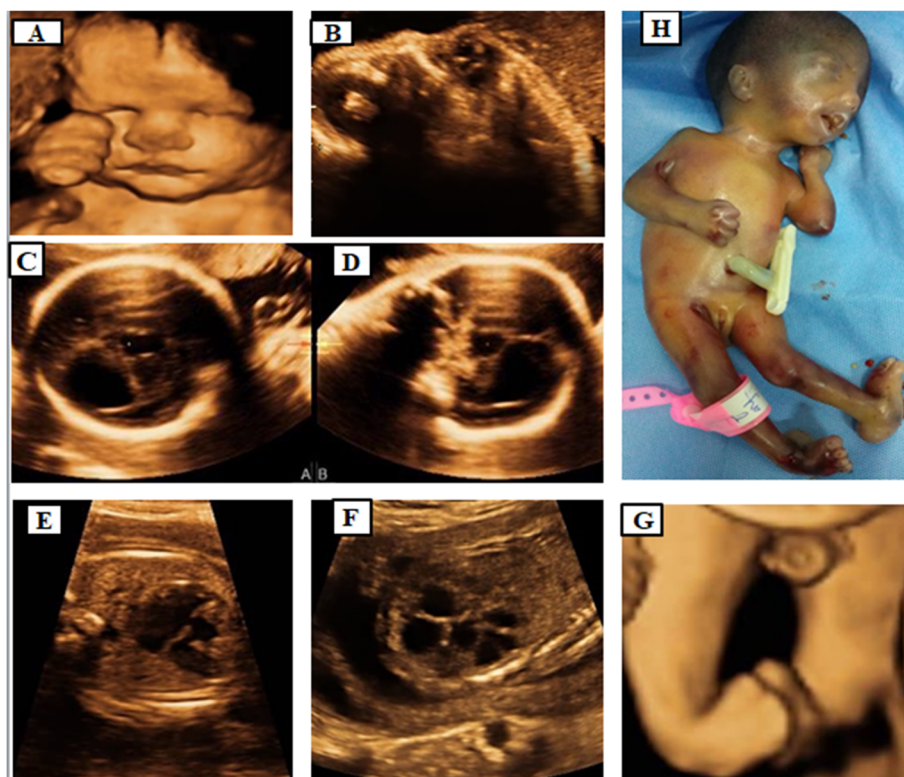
Fetus at 20 weeks' gestational age with ultrasound findings of Walker Warburg syndrome. a Three-dimensional surface rendering of the fetal face showing bilateral microphthalmia and a clenched hand. b Axial US through the orbits showing asymmetric affection with the left eye demonstrating homogeneous opacity of the lens in the left eye consistent with cataract, and the right eye showing echogenic band consistent with hyperplasia of the vitreous chamber. c Axial trans-ventricular plane of the fetal head demonstrating agenesis of corpus callosum, dilatation of the third ventricle, and the anterior and posterior horns of the lateral ventricles. d Axial transcerebellar plane of the fetal head showing cerebellar hypoplasia and vermis agenesis with open fourth ventricle communicating with the cisterna magna and non-expanded posterior fossa. e Fetal echocardiogram demonstrating AVSD (atrial ventricular septal defect). f Coronal US image of multicystic dysplastic kidney (MCDK) showing enlarged kidney with several subcortical small cysts. g Three-dimensional surface rendering mode of lower extremities showing hyperextended knees and bilateral talipes with deformed lower limbs. h Postmortem image confirms the presence of the above findings
